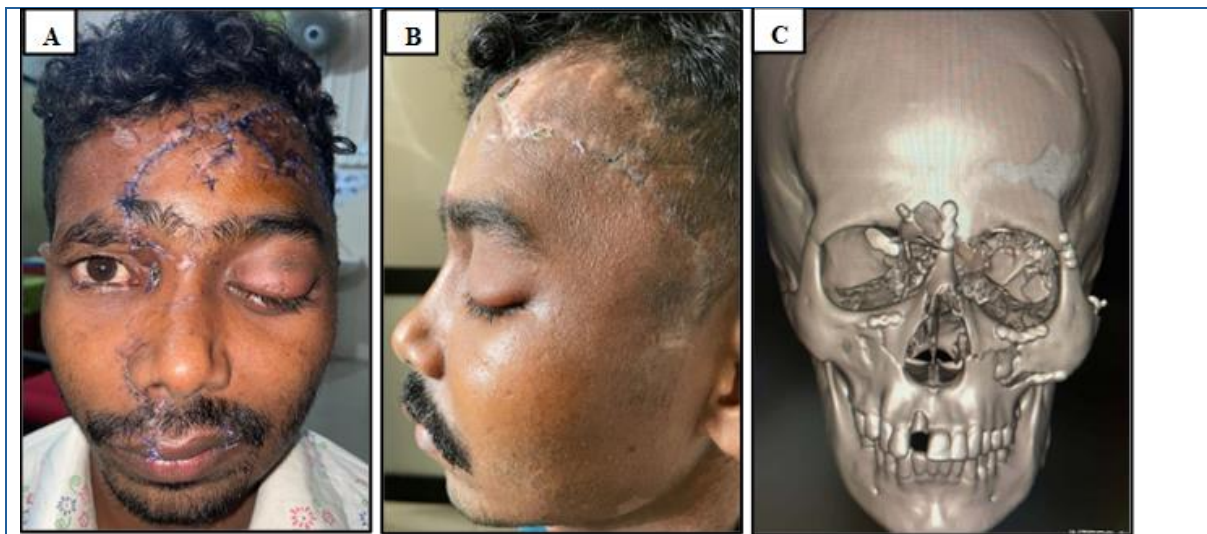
A&B Post-operative, C: 3D CT evaluation of hard tissue reconstruction
